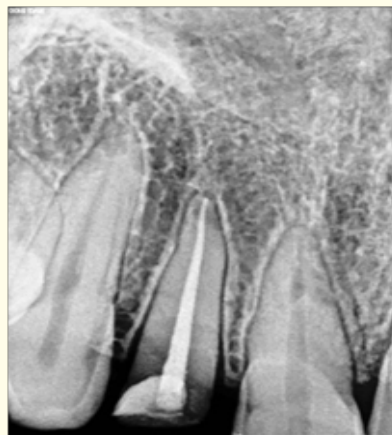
Radiograph of completed root canal treatment
